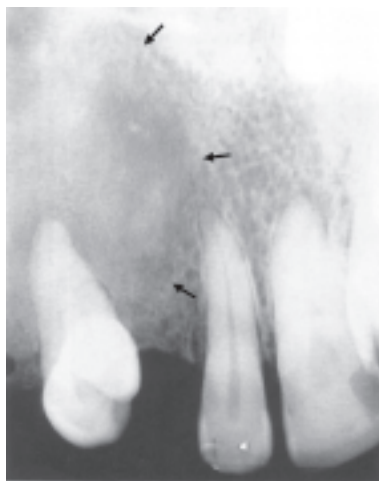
Periapical of the upper right maxilla showing the generalized radio-lucency with the fine internal trabeculation of monostotic fibrous dysplasia, giving a ground glass appearance. The almost imperceptible junction between abnormal and normal bone is arrowed
